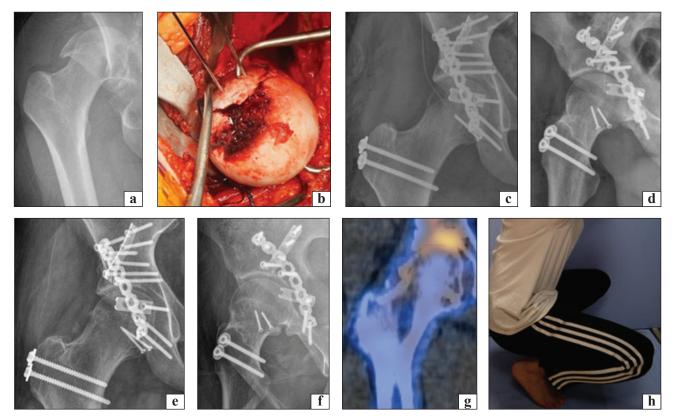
Pipkin type IV femoral head fracture (a), surgical dislocation of the hip (b), stable fixation and congruence achieved (c, d), consolidation 8 months after surgery (e, f), single-photon emission CT (blood flow preserved) (g), function satisfactory (h) [25]
